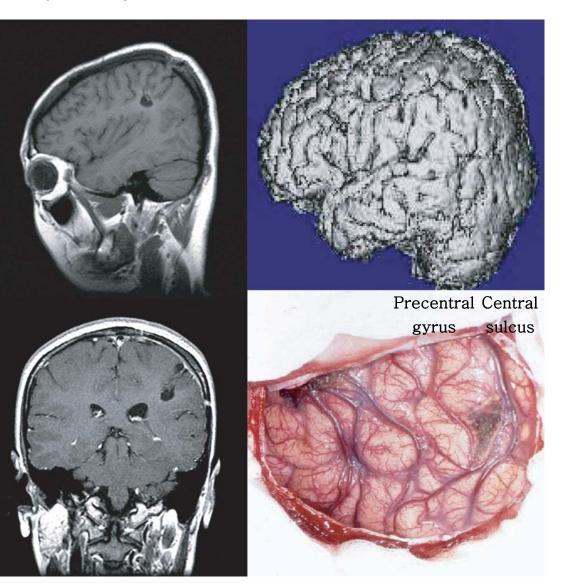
(Left) T1 sagittal and coronal MR images showing the complete removal of CA. (Right) In order to minimize the damage of the precentral gyrus, corticotomy was performed at the margin of the central sulcus that was nearest to the lesion
